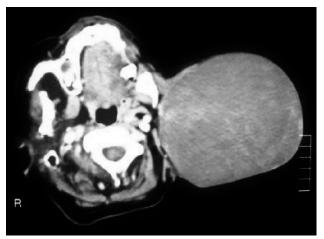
The computed tomography image with contrast demontrates a heterogenously enhancing solid, encapsulated mass with apparently regular edges. The lesion originates from superficial lobe of the parotid gland with exophytic extension laterally.
